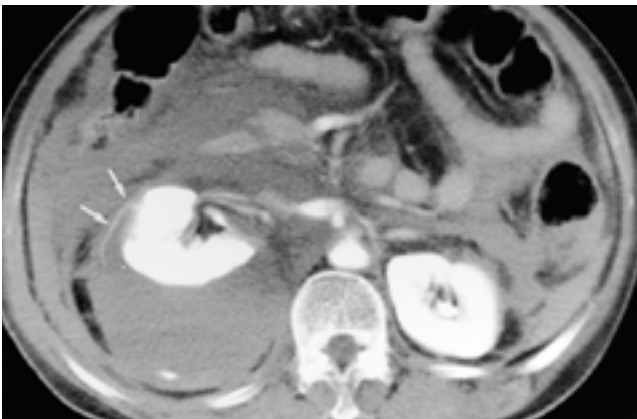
CT prior to angiographic embolization shows large amounts of fluid collection, suggesting hematoma in perirenal and pararenal spaces, and peritoneal cavity. Also notes curvilinear strand-like enhancement from lateral aspect of renal capsule, which suggests bleeding focus (arrows).
